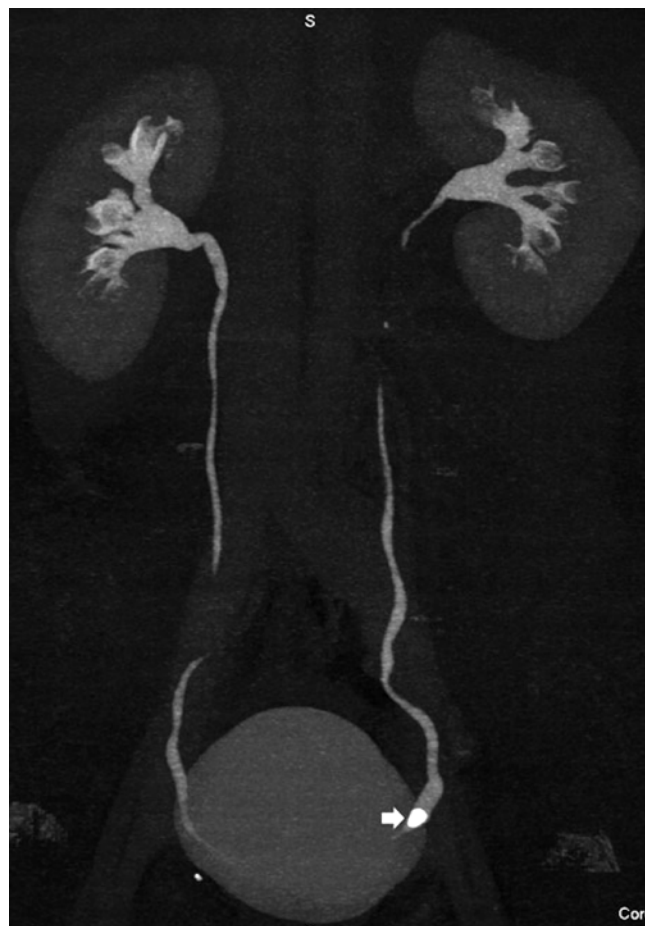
CT urography. Maximum intensity projection. A calculus is visualised in the distal ureter (*arrow*) (Courtesy of Prof. E. Quaia)
